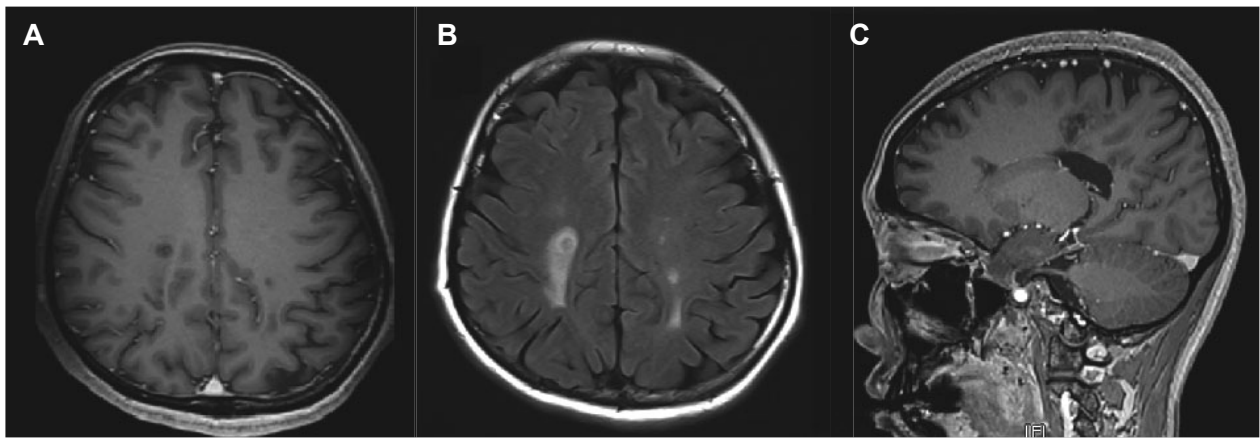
Post-treatment MRI: (A) Regressive change under T1-weighted axial MRI. (B) Residual focal edema under T2-FLAIR axial MRI. (C) No contrast enhancement under T1-weighted sagittal MRI.
